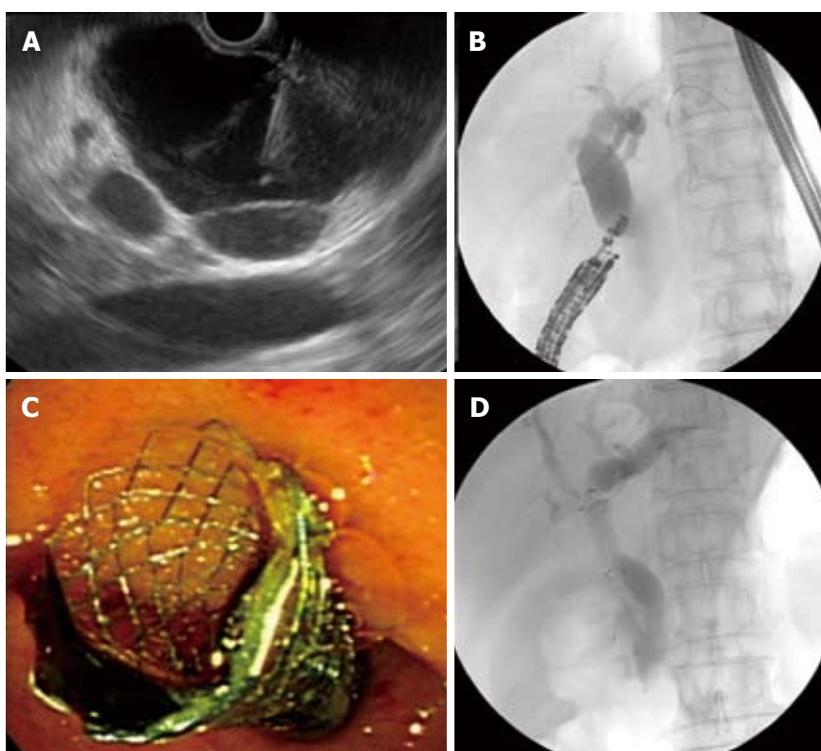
Endoscopic ultrasound-guided choledochoduodenostomy. A: The extrahepatic approach was carried out using an echoendoscope in the duodenal bulb, permitting imaging of the choledochus. Bile duct puncture was carried out with a 19-gauge needle; B: A 0.035-inch guidewire was introduced through the endoscopic ultrasonography-needle and advanced in a retrograde fashion; C and D: A fully covered metal stent was placed under echoendoscopic and fluoroscopic view.
